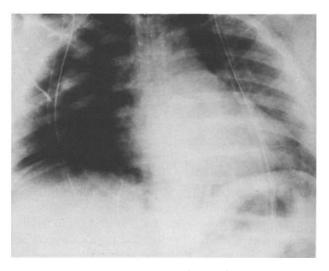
Chest X-ray demonstrating surgical emphysema, pneumoretroperitoneum and pneumoperitoneum. The air passage to the peritoneium is clearly shown as demarcated lines of air on both sides of the thoracid and abdominal aorta
